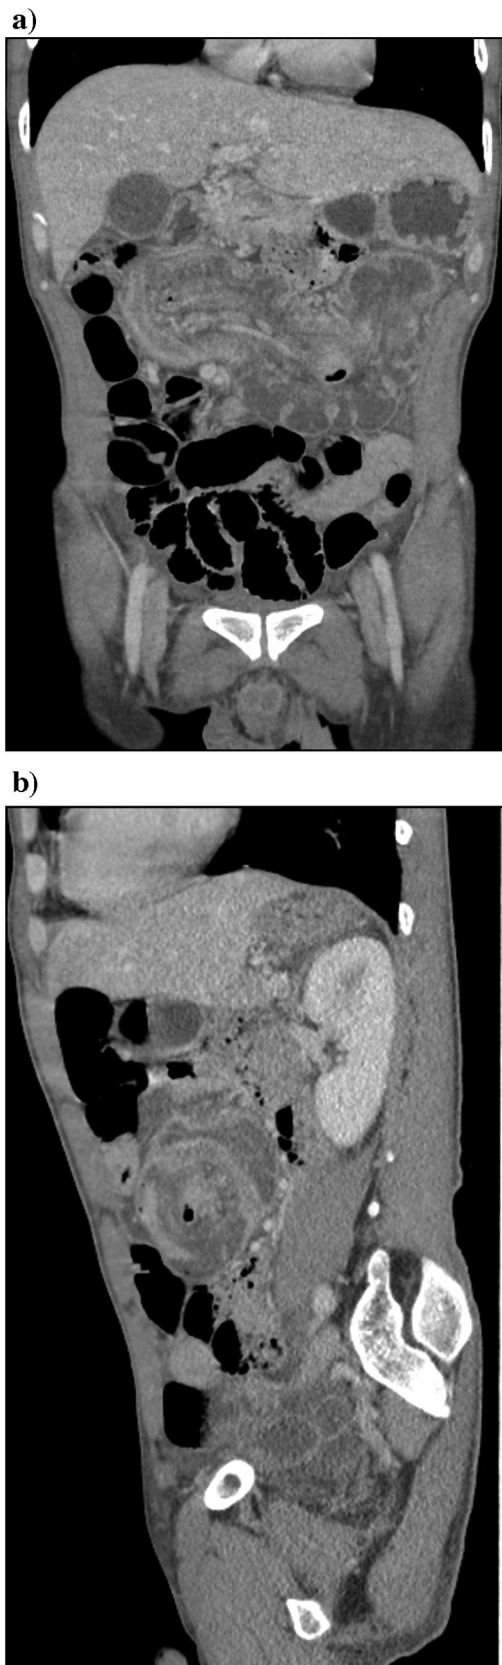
Computed tomography scan demonstrating a colo-colonic intussusception with the cecum and ascending colon extending into the transverse colon. (a) coronal view (b) sagittal view.
